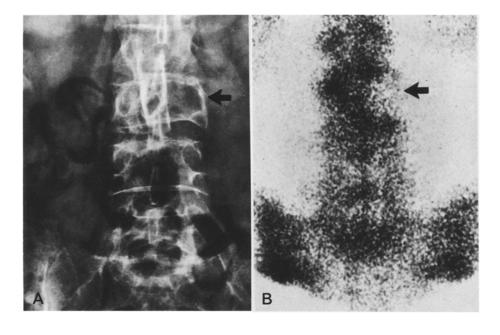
False-negative scan in woman with breast carcinoma. A Radiograph reveals lytic metastatic lesion of body and left pedicle of third lumbar vertebra (arrow). B Scan discloses corresponding deficit in isotope activity (arrow)
